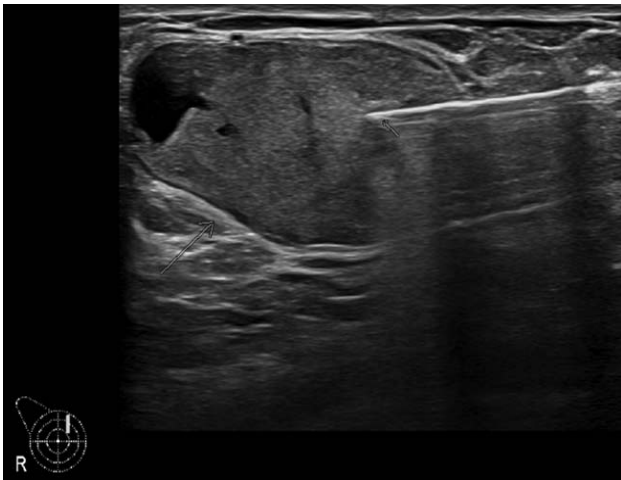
Ultrasound guided biopsy of right breast lesion at 1.00. Short arrows pointing towards the tip of needle within lesion and long arrows shows solid lesion with cystic spaces.
